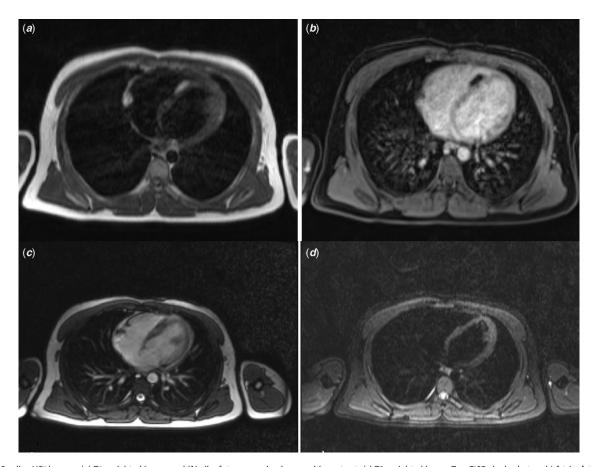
Cardiac MRI images. (a) T1-weighted image and (b) vibe fat suppression image with contrast. (c) T2-weighted image TrueFISP single shot and (d) trim fat suppression image.
